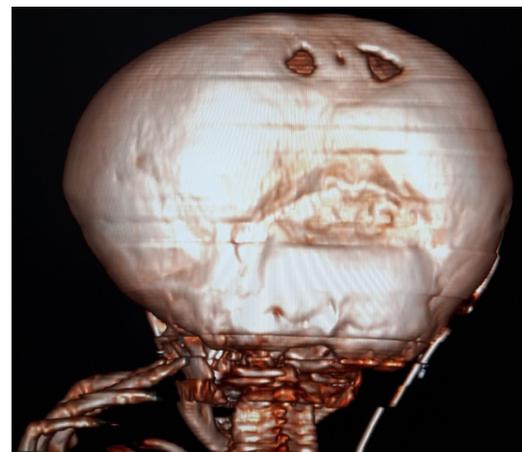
A CT scan of the head by using volume rendering technique. This right anterior oblique (RAO) view which shows an enlarged skull. Some motion artifact caused some distortion of the image due to the seizures and the unstable condition of the patient, even though, sedation was given and fixation was used, but the patient was still moving.
